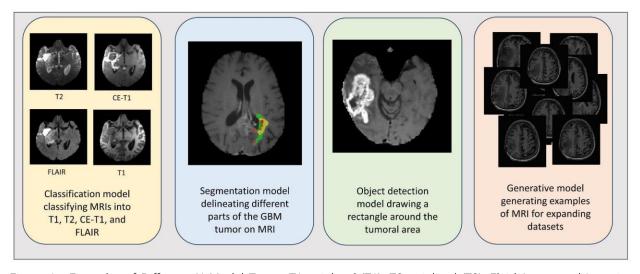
Examples of Different Al Model Types: T1-weighted (T1), T2-weighted (T2), Fluid-Attenuated Inversion Recovery (FLAIR), Contrast-Enhanced T1-weighted (CE-T1), Glioblastoma (GBM), Magnetic Resonance Imaging (MRI).
